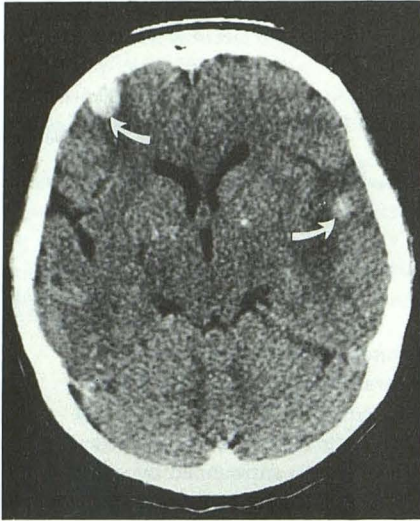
Case 1. Axial CT scan done 2 hours after clinical onset demonstrates two sharply circumscribed hyperdense hematomas in the right middle frontal gyrus and the left superior temporal gyrus (arrows).
